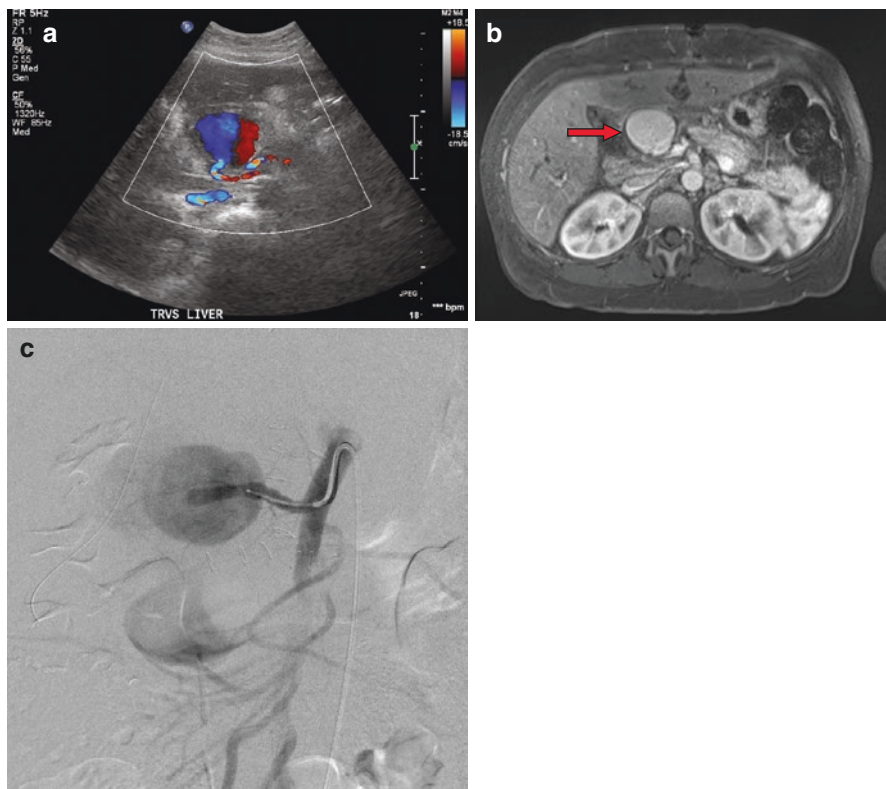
Extrahepatic hepatic artery pseudoaneurysm: (a) Sonographic images demonstrating a “yin-yang” sign consistent with a pseudoaneurysm. (b) Post-contrast MRI shows the presence of an extrahepatic pseudoaneurysm. (c) DSA confirms the presence of the pseudoaneurysm
